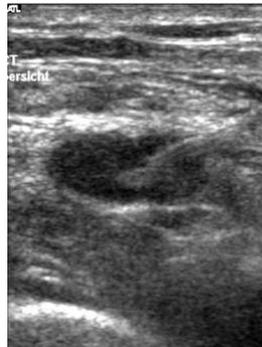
Neck lymph node metastasis of an epidermoid lung cancer (a). Ultrasound guided fine needle aspiration biopsy of a supraclavicular lymph node (b), the needle is shown.
